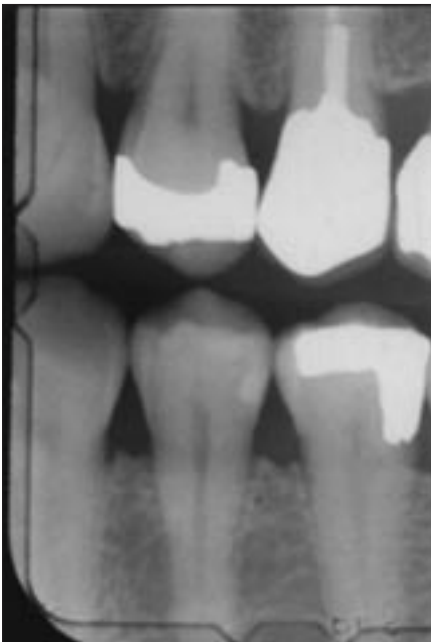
Radiograph of a facial slot Class II restoration (distobuccal 34) after 2¹/₂ years.
